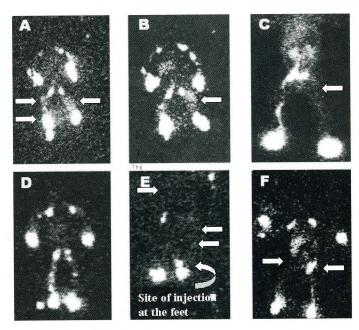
Lymphoscintigraphy in newborns: Images and Transport Index (T.I.). Panel A: Dermal back flow (DBF) at the left lower limb and right delayed tracer drainage (arrows) in newborn affected by congenital leg lymphedema and chylothorax (T.I. 18). Panel B: Newborn with left leg lymphedema and a moderate quantity of chylous ascites. DBF at the left lower limb (arrow) (T.I. 18). Panel C: Absent visualization of left inguinal nodes in newborn (arrow) with peripheral left leg lymphedema, chylothorax and chyloperitoneum (T.I. 27). Panel D: Normal peripheral lymphoscintigraphic pattern in newborn with chylous ascites (T.I. <10). Panel E: Peripheral left leg and right arm congenital lymphedema. Absent visualization of right axillary (single arrow) and left inguinal nodes (double arrow) (T.I. 36) Panel F: DBF at the left thigh and absent visualization of right inguinal lymph nodes in newborn with peripheral leg lymphedema and chylous ascites (T.I. 27). A slight diffusion of the tracer is evident at the site of chylothorax and chyloperitoneum in all lymphoscintigraphic patterns.
